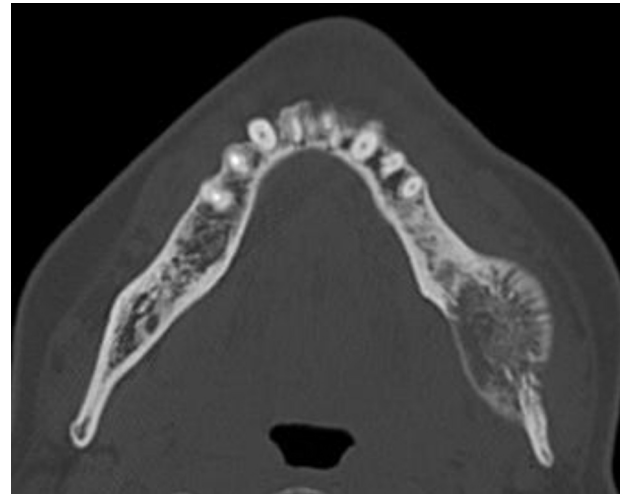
CT shows an osteoblastic lesion with expansion of both cortical plates in the region of the ascending ramus of the left mandible.
